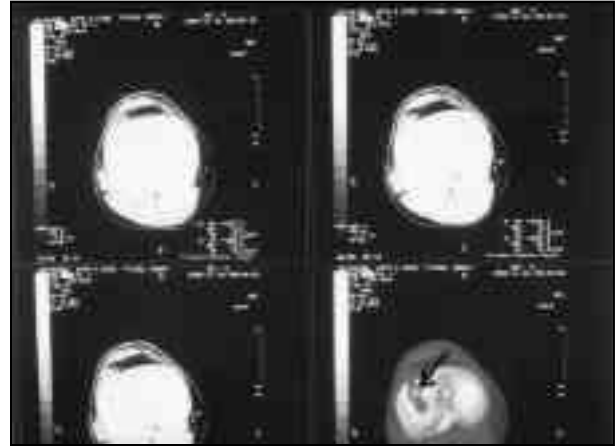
CT image demonstrates the same lesion eroding the tibial articular surface
